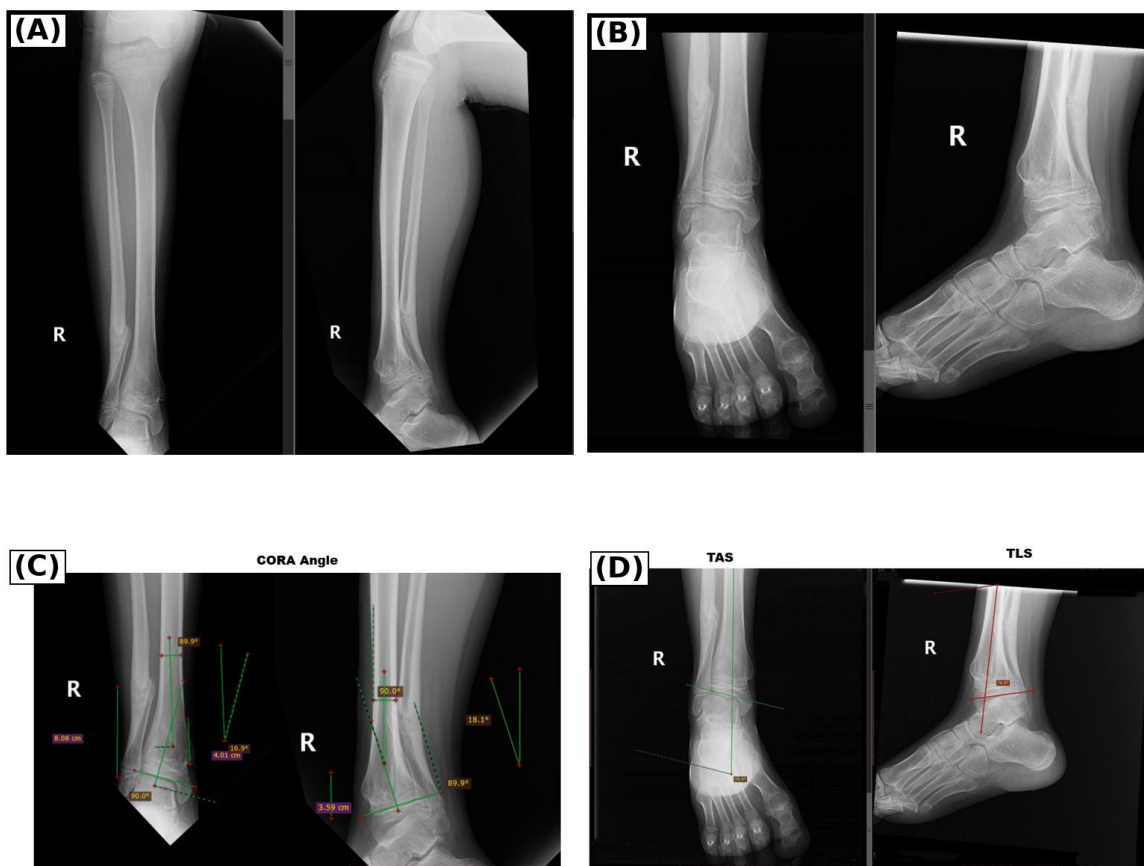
Preoperative radiographic assessment and deformity analysis of the right leg and ankle. (A) Anteroposterior and lateral views of the tibia and fibula showing distal tibiofibular malunion. (B) Anteroposterior and lateral ankle views demonstrating articular-surface obliquity. (C) Center of rotation of angulation (CORA) analysis quantifying 16.9° of coronal-plane and 18.1° of sagittal-plane angulation. (D) Measurement of the tibial anterior surface (TAS, 76.4°) and tibial lateral surface (TLS, 76.0°) angles.
